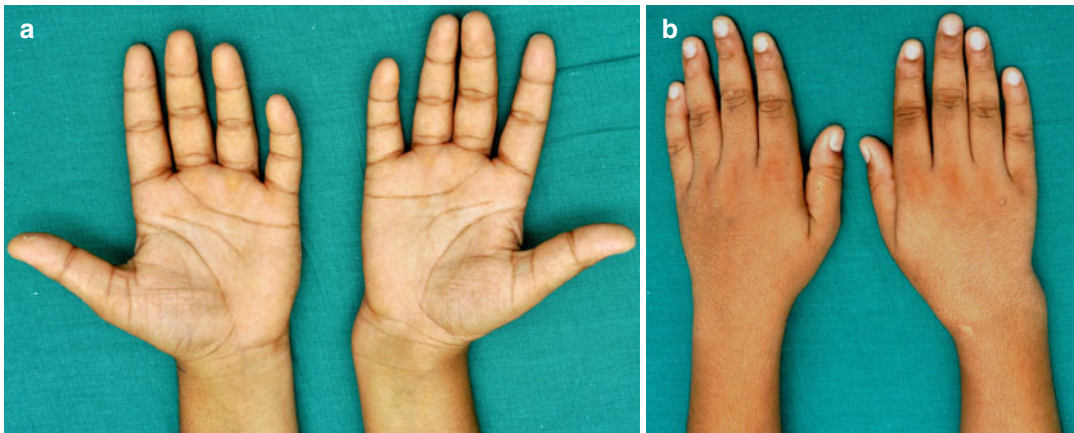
Appearance of the wrist of a girl with Madelung deformity (a–c); the left wrist is more severely affected. Radiograph of the wrist (d, e) shows the characteristic
